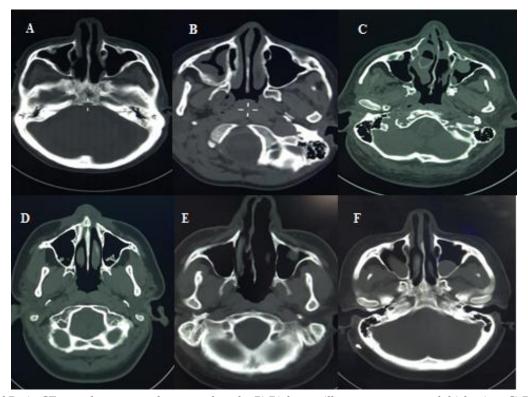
A) Axial Brain CT scan shows normal paranasal study. B) Right maxillary antrum mucosal thickening. C) Bilateral maxillary antrum polipoidal mucosal thickening and hypertrophied inferior turbinates. D) Peripheral inflammatory sinus calcification E) Bilateral maxillary antrum polipoidal mucosal thickening and hypertrophied inferior turbinates. F) Bilateral maxillary antrum polyp and retension cyst.
